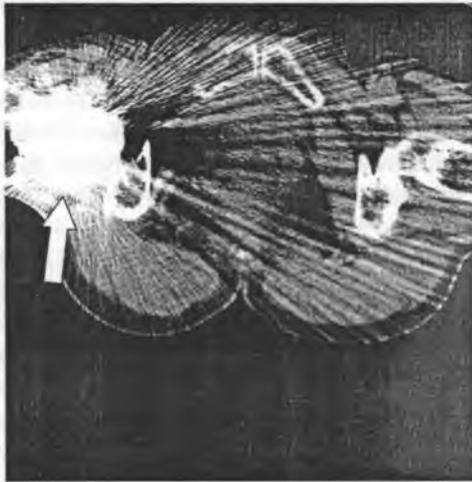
Streak artifacts generated by hip prosthetic material (arrow) that substantially degrade CT image quality and make it hard for the radiologist to evaluate adjacent structures
